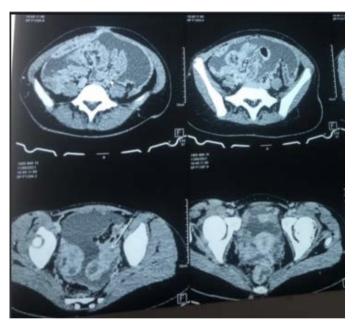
Abdominal-pelvic CT scan showing 2 latero-uterine masses with heterogeneous contrast.
